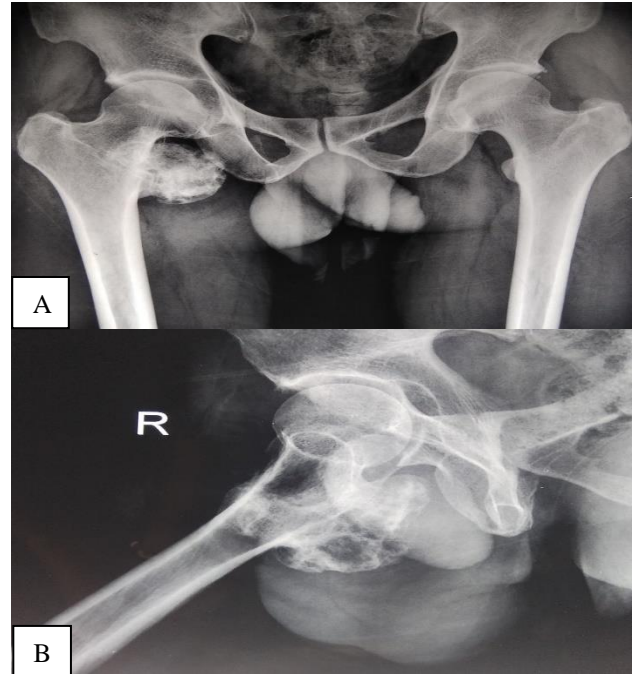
Plain radiographs of the pelvis region (A) anteroposterior view and (B) lateral view.
